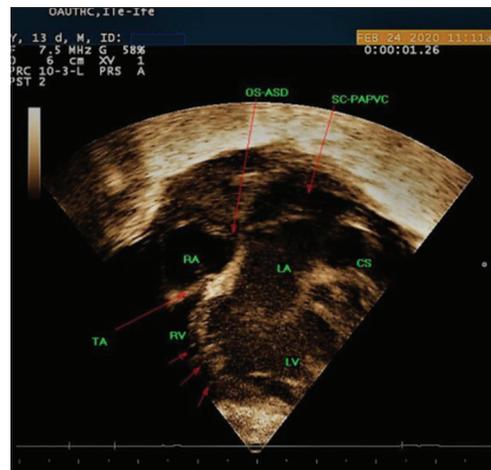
Echocardiogram. CS: Dilated coronary sinus, LA: Left atrium, LV: Left ventricle, RA: Right atrium, RV: Right ventricle, OS-ASD: Ostium secundum-type atrial septal defect, SC-PAPVC: Supracardiac chamber-type partial anomalous pulmonary venous circulation, TA: Tricuspid atresia and the arrows depict multiple muscular ventricular septal defects
